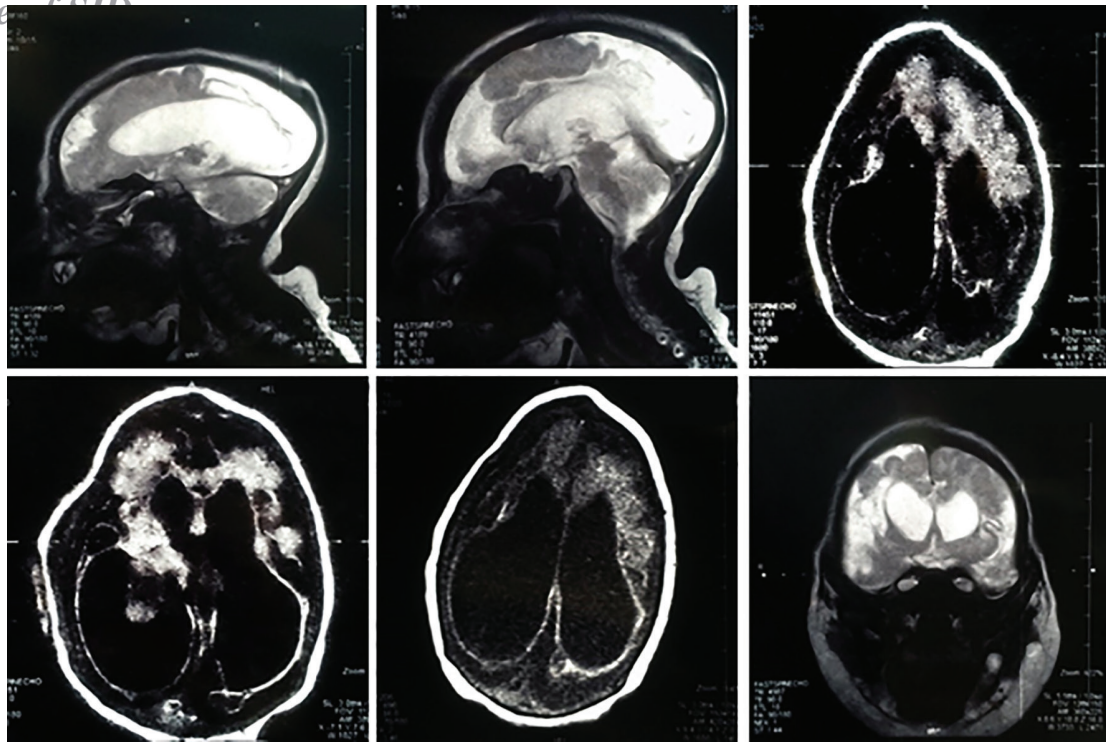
Sagittal T2-weighted MRI demonstrating the severe encephalomalacia along with brain atrophy (A,B); Axial fluid-attenuated inversion recovery (FLAIR) demonstrating ventriculomegaly and multiple intraparenchymal hemorrhages.(C,D,E); coronal T2-weighted MRI demonstrating right frontoparietal brain atrophy.
